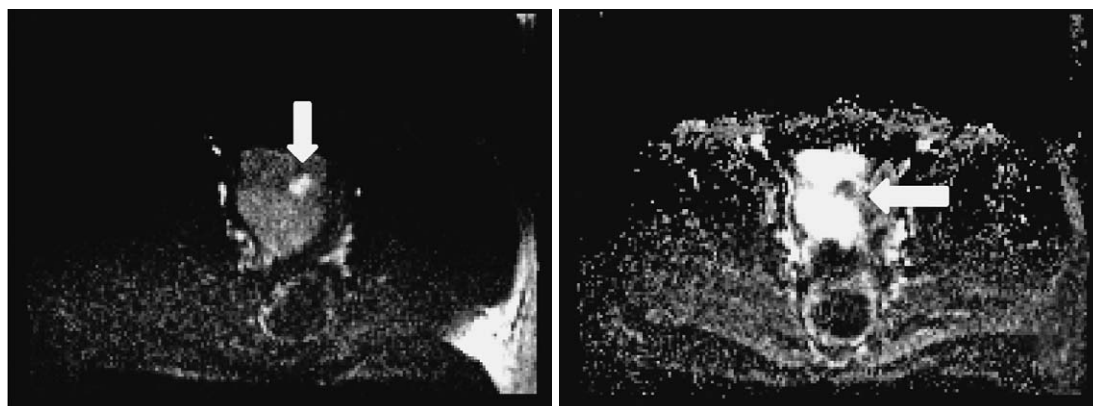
DWI (on the left) and ADC map (on the right). Urinary bladder tumor (arrows) of high intensity on DWI and of low intensity on ADC map depicting diffusion restriction characteristic for malignant lesions.
